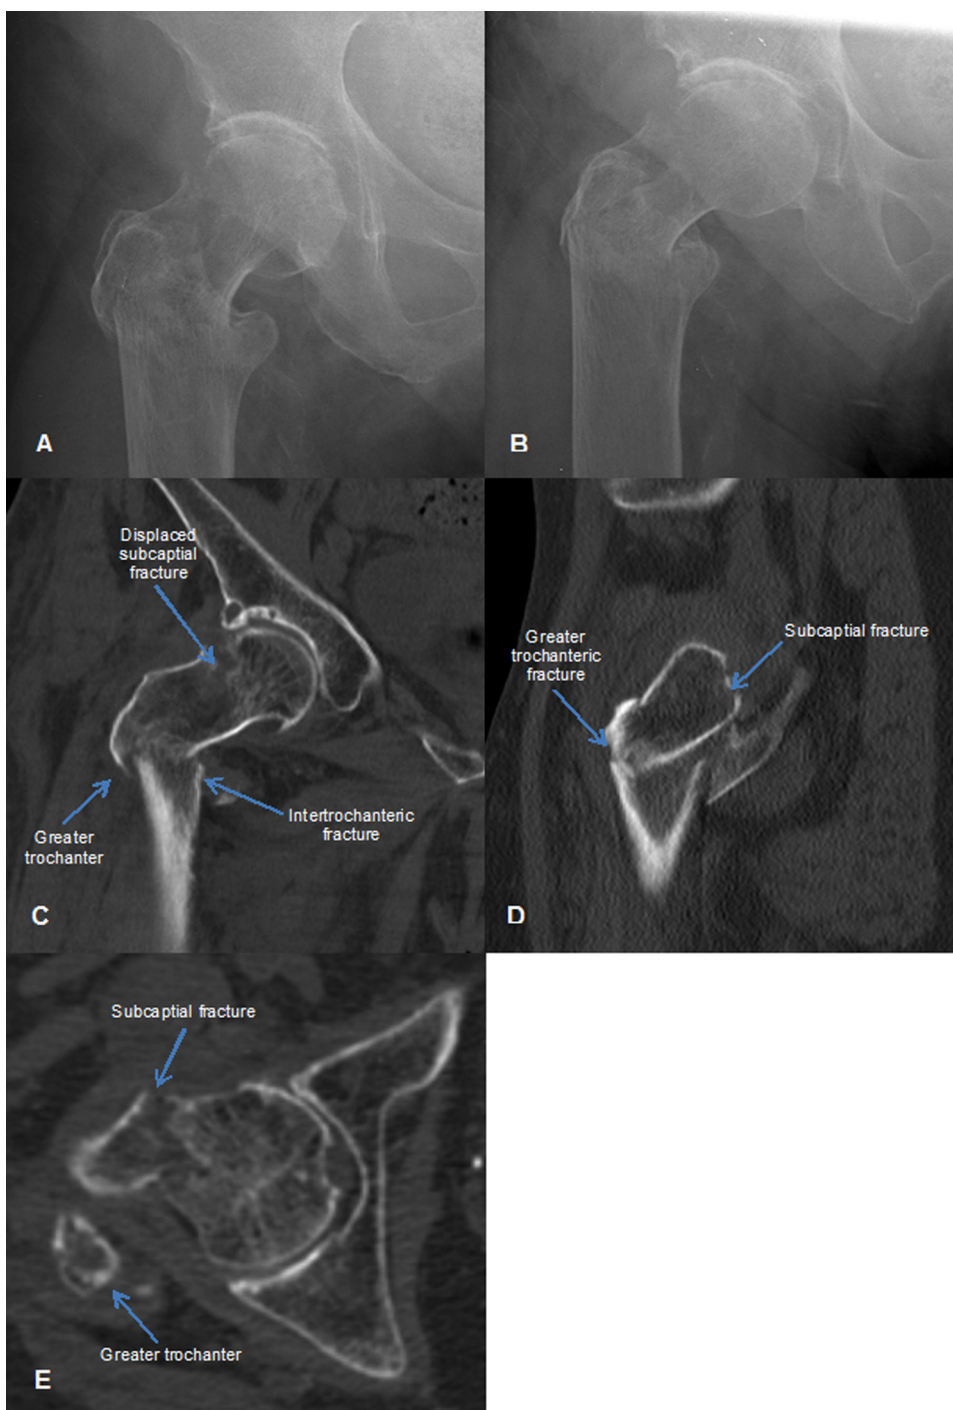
A. AP X-ray, B. Oblique X-ray, C. Coronal view of displaced subcapital fracture and concomitant intertrochanteric fracture on CT D. Coronal view further posteriorly demonstrating greater trochanteric fracture on CT E. Displacement of subcapital fracture seen on axial view on CT.
